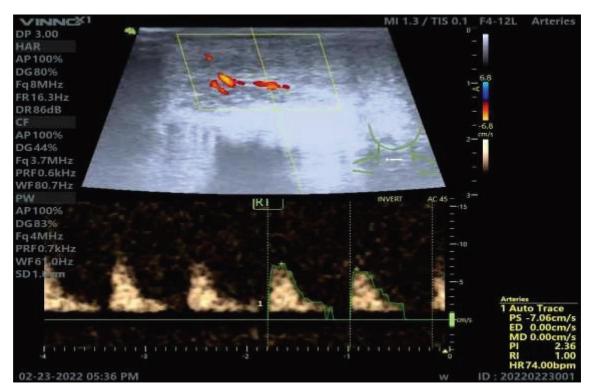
Penile artery Doppler for male case aged 68 years old diabetic for 6 yr and hypertensive for 10 yr. Coronary angiography showed severe double vessel affection. ILFE-5 score was 7. On penile artery Doppler; PSV was 7.06 cm/s.
